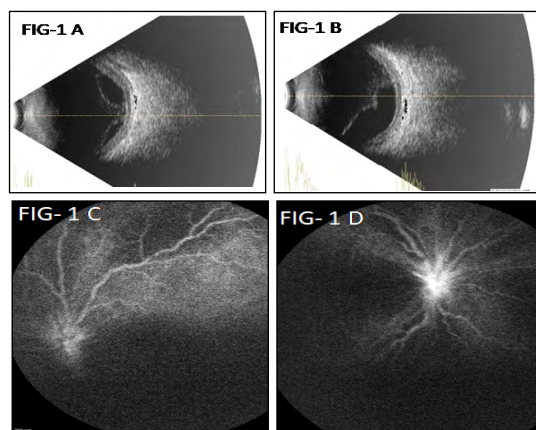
& 1B - Ultrasonography B-scan report shows bullous exudative retinal detachment with choroidal thickening in right eye (OD) and left eye (OS) respectively.
